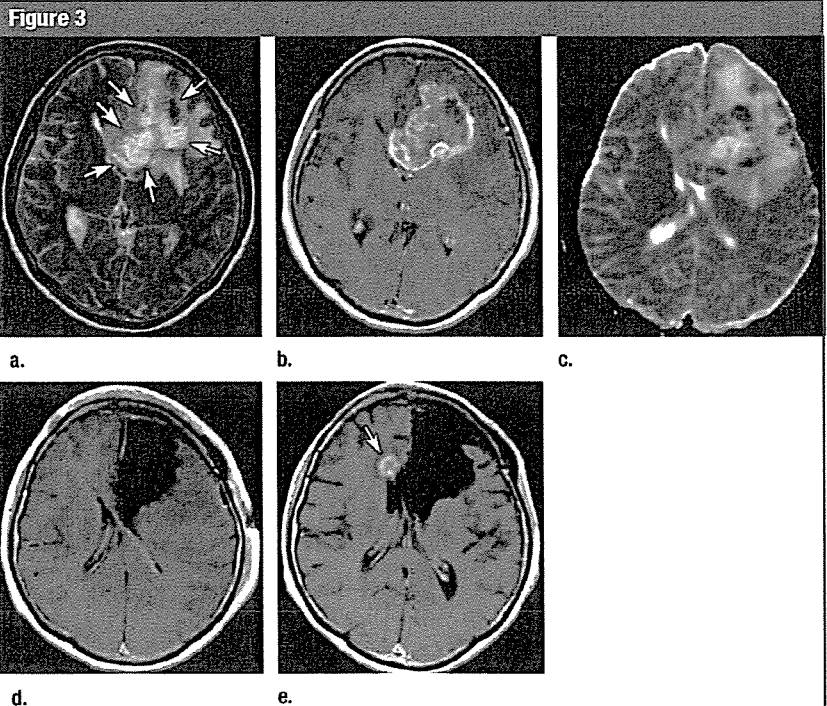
GBM in 56-year-old woman. Transverse (a) preoperative T2-weighted MR image (3600/96), (b) contrast-enhanced T1-weighted MR image (440/14), and (c) ADC map show irregularly shaped enhancing tumor (arrows in a) with peritumoral edema in left mediofrontal lobe. Minimum ADC value was $0.72 \times 10^{-3} \text{ mm}^2 \cdot \text{sec}^{-1}$. (d) Postoperative contrast-enhanced transverse T1-weighted MR image (440/14) shows gross total removal of the tumor. (e) Contrast-enhanced transverse T1-weighted MR image (440/14) 9 months after surgery shows a patchy enhancing lesion (arrow). The lesion enlarged later, and gamma knife therapy was performed. With further progression of the disease, the patient died 1.5 years after initial treatment.
